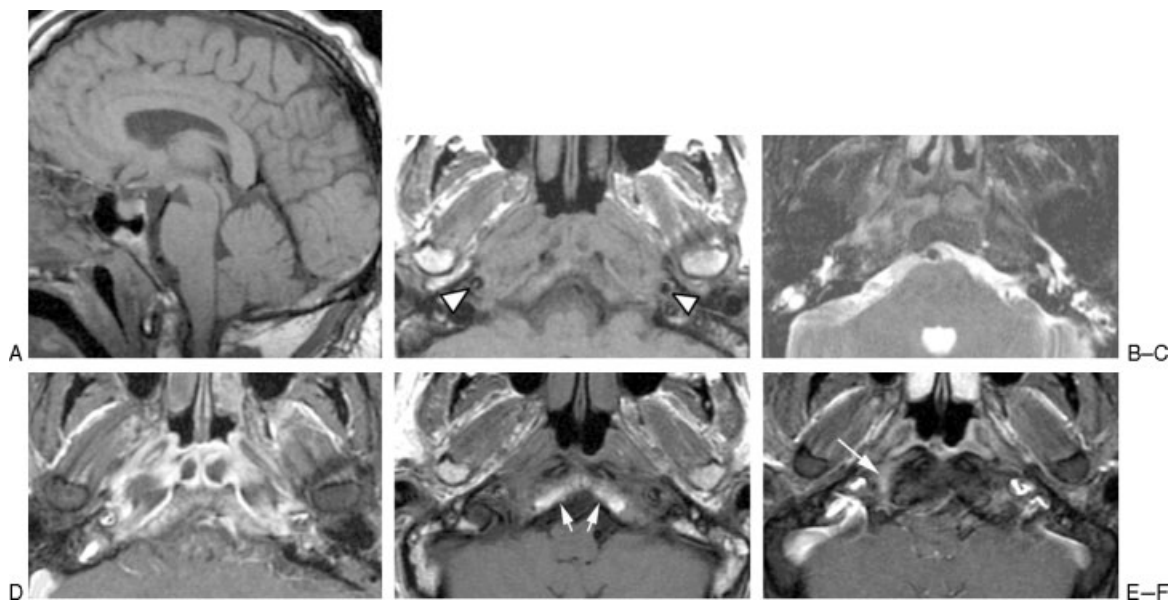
(A) Sagittal T1-weighted image demonstrates abnormally low signal intensity in the inferior clivus. (B) Axial T1-weighted image demonstrates abnormal soft tissue isointense to muscle infiltrating submucosally within the nasopharyngeal soft tissues, extending posteriorly to abut the carotid arteries (arrowheads), and replacing the normal hyperintense fatty marrow within the lower clivus. (C) Axial T2-weighted fast spin-echo image with fat saturation demonstrates mildly increased signal intensity within the infiltrated soft tissue compared with that of normal muscle. In addition, there is fluid in the mastoid air cells and middle ear cavities bilaterally, presumably related to Eustachian tube dysfunction or obstruction or both. (D) Contrast-enhanced axial T1-weighted spin-echo image with fat saturation demonstrates moderately intense enhancement of the infiltrative soft tissue. Some areas of nonenhancement may represent areas of infarcted or necrotic muscle. (E) Axial T1-weighted spin-echo image from a follow-up MR examination 16 months after the initial study demonstrates normalization of clival signal intensity (white arrows), as well as considerable reduction in bulk of the previously noted abnormal pre- and paraclival soft tissue. (F) Contrast-enhanced axial T1-weighted spin-echo image with fat saturation from the same follow-up examination demonstrates marked reduction of enhancement, with a normal appearance to the nasopharynx and prevertebral muscles. An ill-defined area of linear enhancement just at and anterior to the hypoglossal canal on the right (arrow) is likely extending along the course of the hypoglossal nerve. Of note, this patient's hypoglossal palsy has persisted despite resolution of all other symptoms. (Figure and description from Chang PC, Fischbein NJ, Holliday RA. Central skull base osteomyelitis in patients without otitis externa: imaging findings. *AJNR Am J Neuroradiol* 2003;24:1310–1316. Copyright © by American Society of Neuroradiology. Reprinted with permission.)
